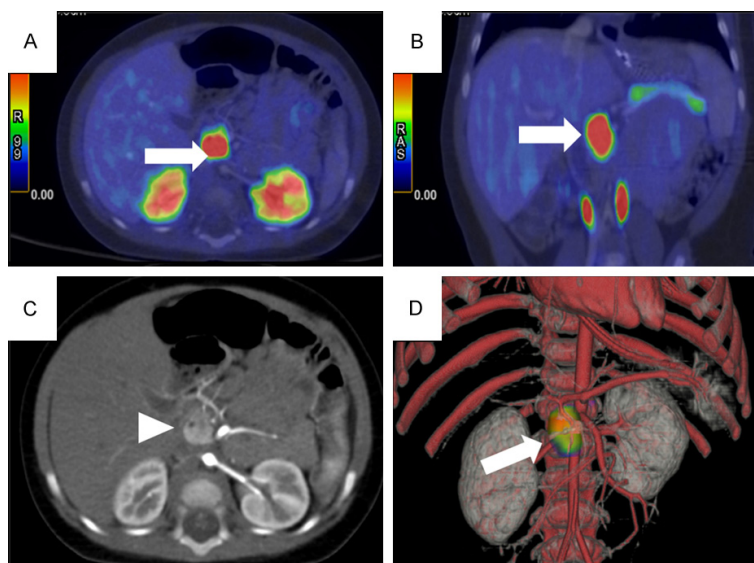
Focal Congenital Hyperinsulinism. Axial (A) and coronal (B) ^{18}F -DOPA PET images show focal PET uptake in the head of the pancreas (arrow). Transverse CT on the arterial phase image (C) shows hyperenhancing CT nodule in the head of the pancreas (arrowhead). Anterior view of 3D volume rendering fusion PET/CT image (D) shows the relationship between the lesion (arrow) and artery vessels.
